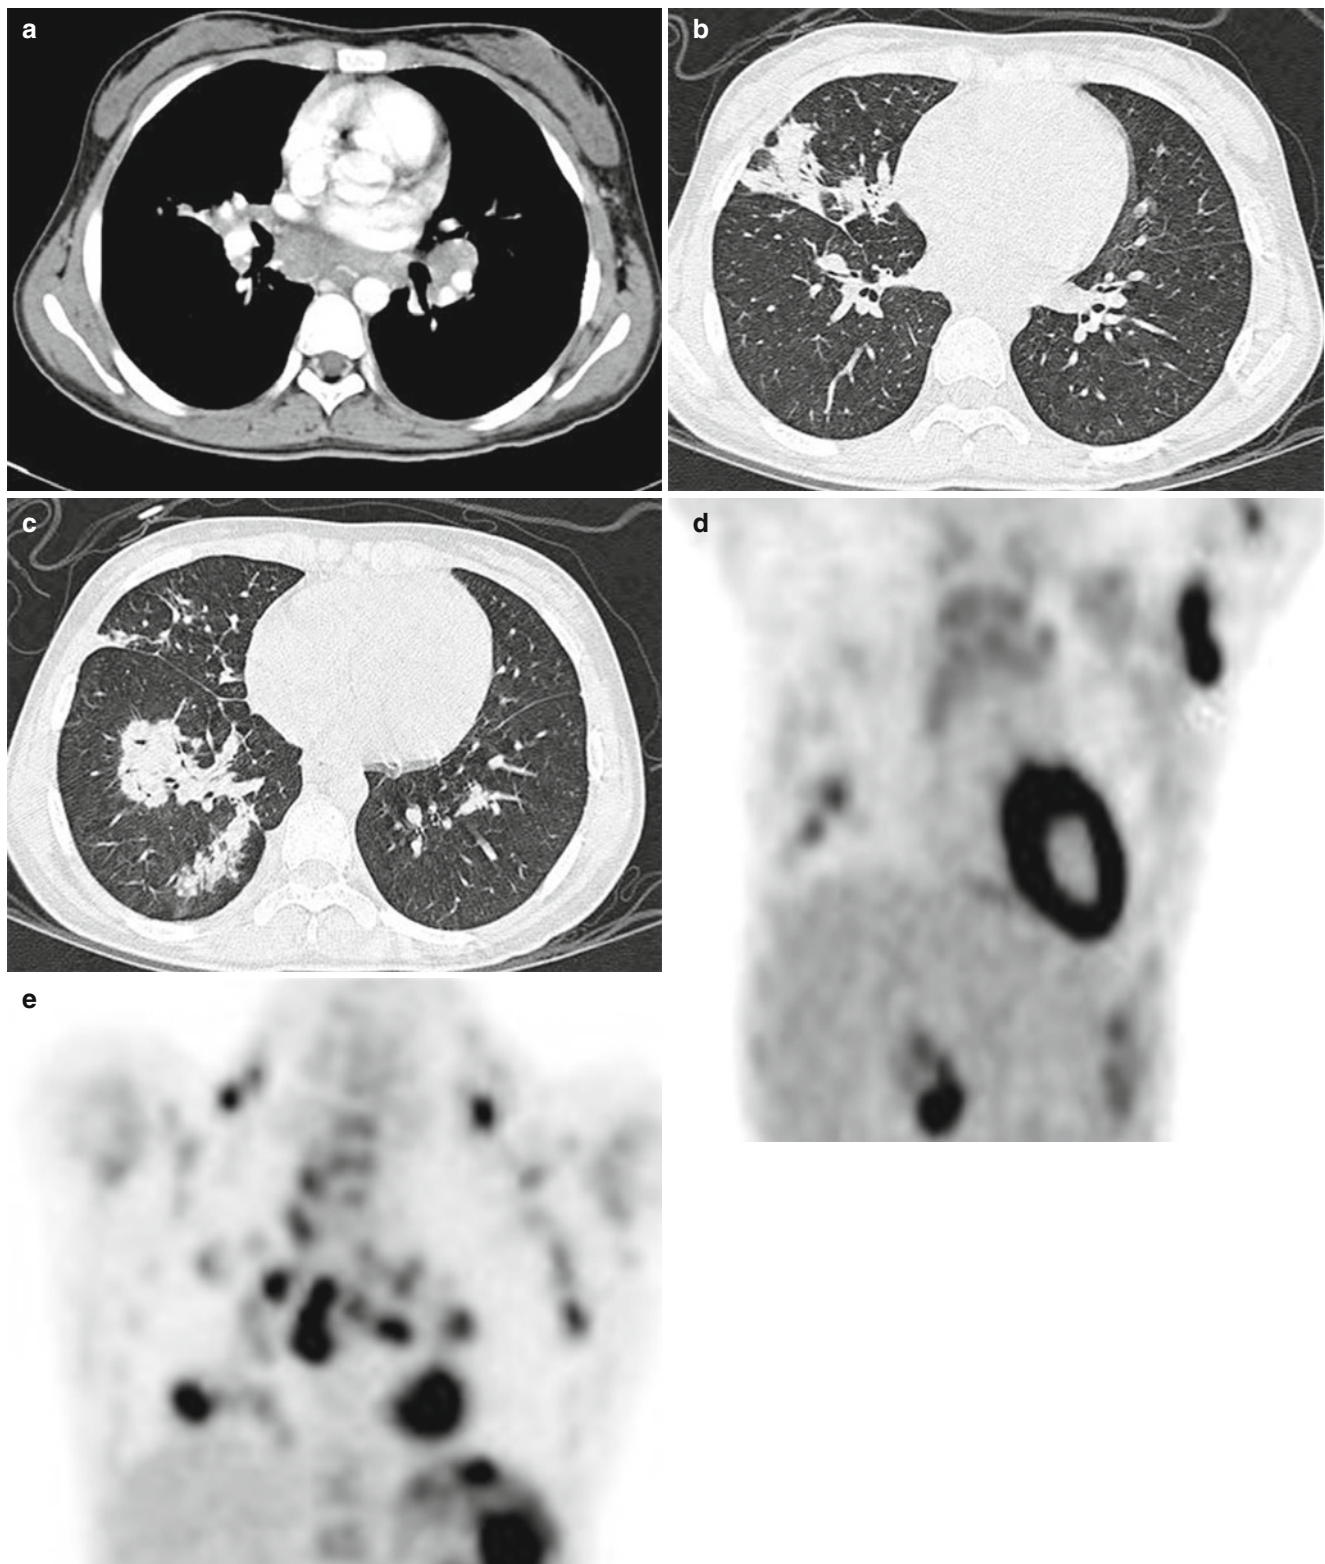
Nodular sclerosing Hodgkin's disease in a 12-year-old girl with cervical lymphadenopathy. (a) Contrast-enhanced CT with mediastinal window shows bilateral hilar and mediastinal adenopathy with homogenous attenuation. (b, c) CT scans with lung window
